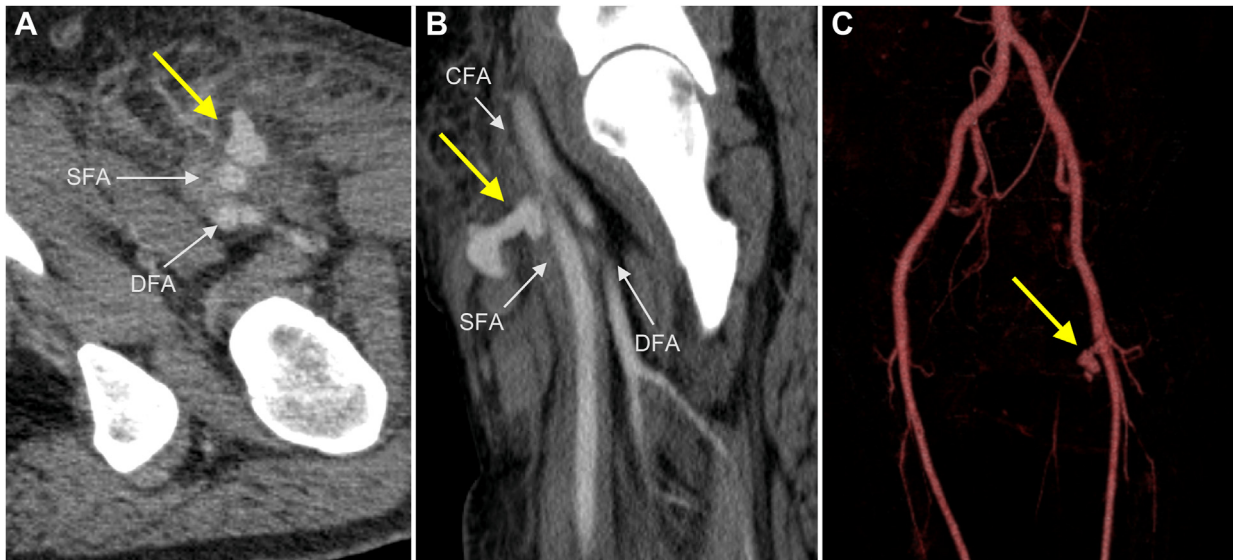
Axial (A) and sagittal (B) preoperative contrast-enhanced computed tomography views showing the 32-mm diameter pseudoaneurysm (yellow arrow). C, Three-dimensional computed tomography angiogram showing the pseudoaneurysm (yellow arrow) originating from the left superficial femoral artery (SFA). CFA, Common femoral artery; DFA, deep femoral artery.
